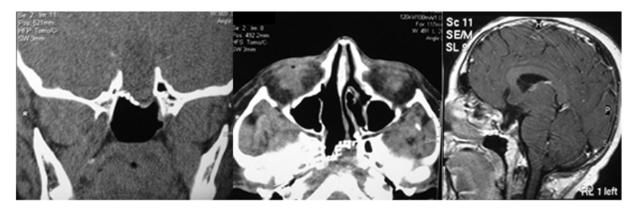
Left: Post-operative coronal CT scan showing the repaired site. Middle: Post-operative axial CT scan showing the reduction of the size of the sac. The titanium mesh is also seen. Right: Sagittal view MRI showing the reconstructed sella.
